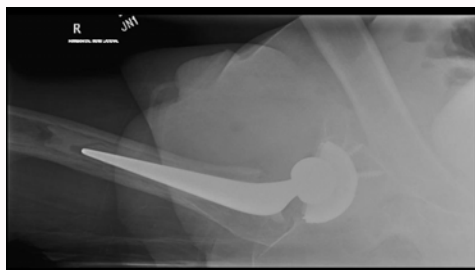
A lateral radiograph of the Right Total Hip Replacement (THR).
